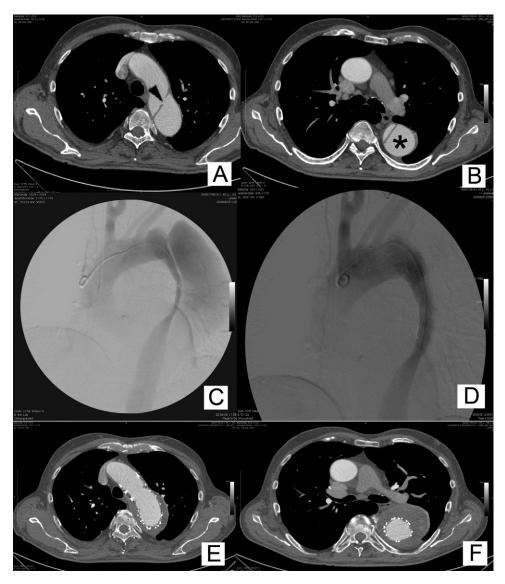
A, Preoperative computed tomography (CT) angiography showing entry (*arrowhead*). B, True and false lumen (*asterisk*). C, Intraoperative angiography before graft deployment. D, Intraoperative angiography after successful graft deployment. E, Postoperative CT angiography showing entry sealing. F, Postoperative CT angiography showing patent graft with thrombosis of the false lumen.
